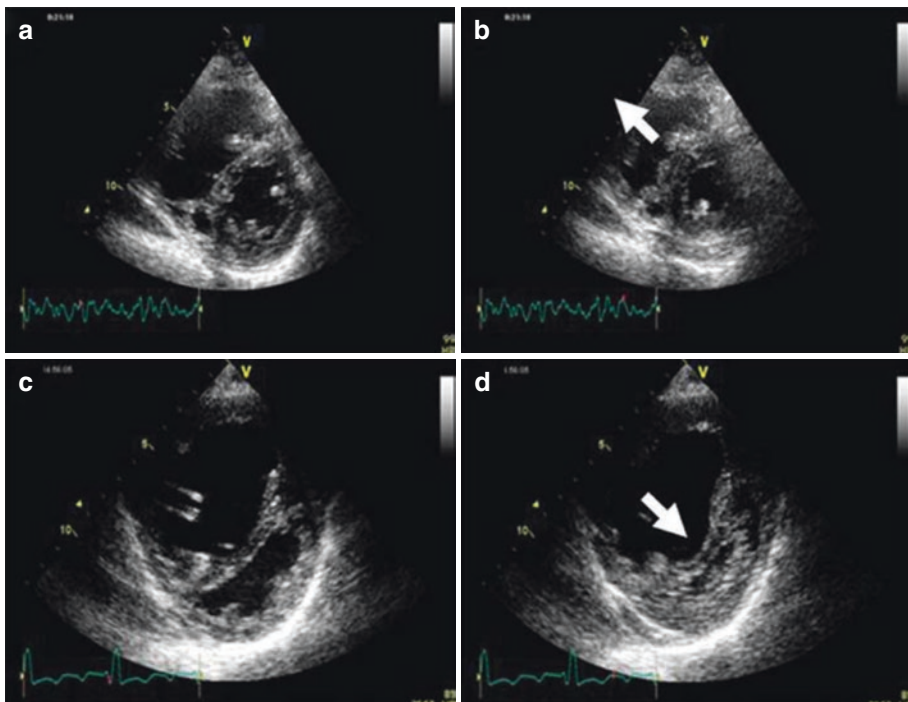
Parasternal short-axis views at the mid-ventricular level. (a, b) Patient with *atrial septal defect type ostium secundum*, consequent right ventricular volume overload, and mildly elevated pulmonary artery pressures—flattening of the interventricular septum at end diastole (a) and recovering of shape at end systole (arrow)
